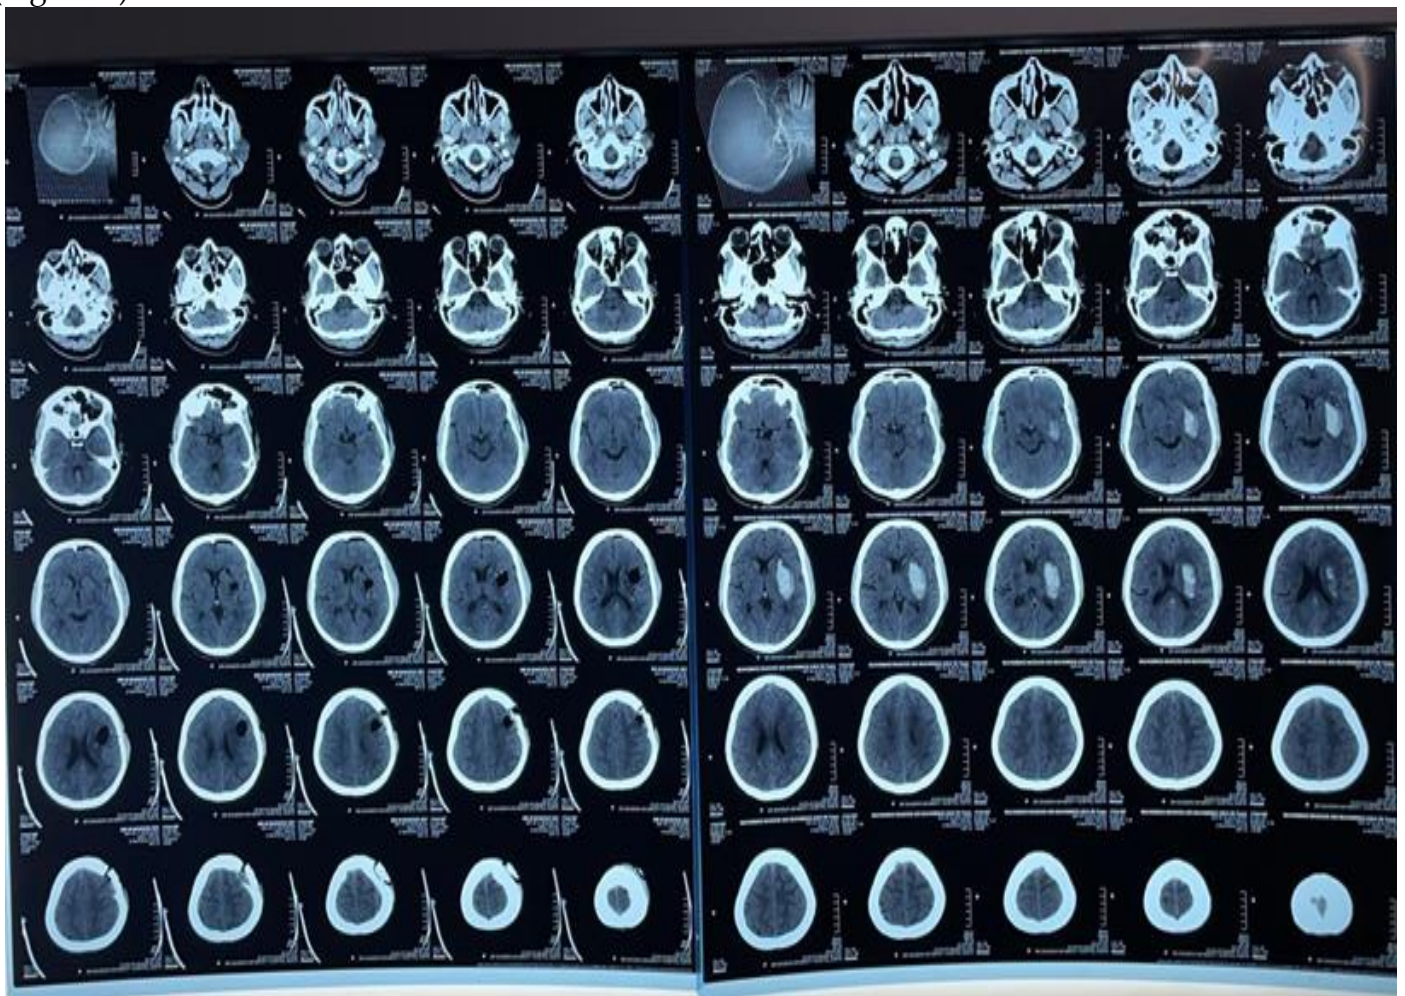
Computed Tomography scan of the patient after surgery
